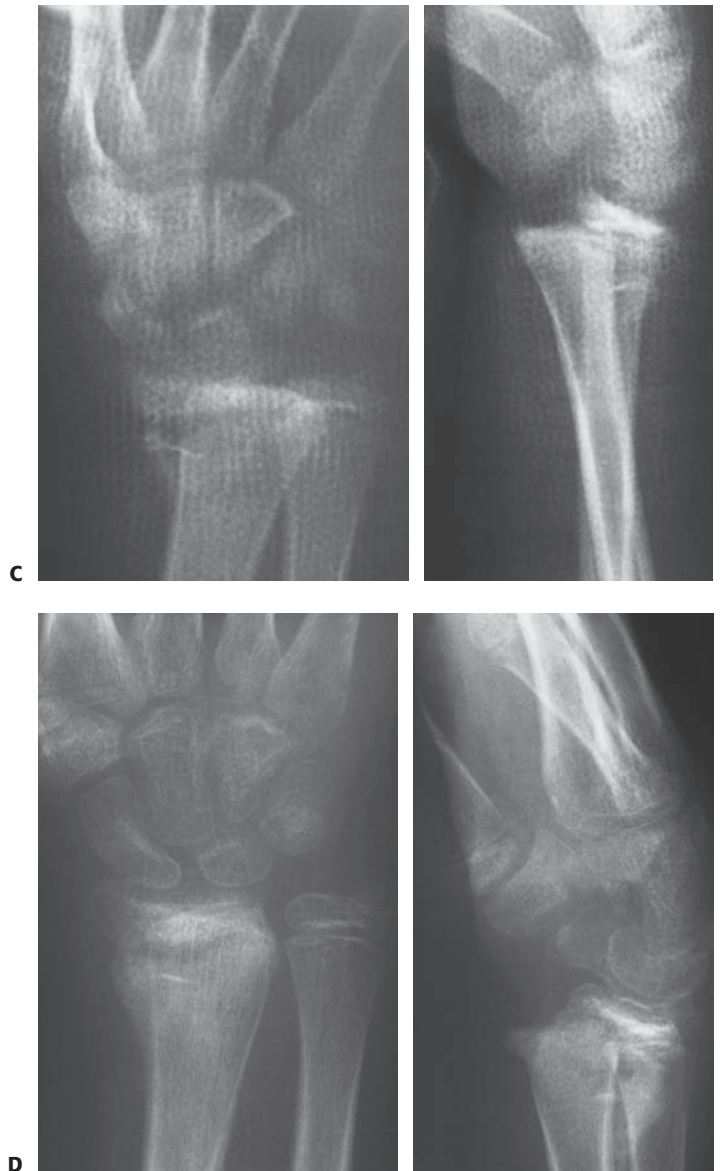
(continued) C: Unfortunately the patient lost reduction after a new fiberglass cast was applied. D: Out-of-cast radiographs show a healed malunion in a similar position to the preradiation radiographs.
